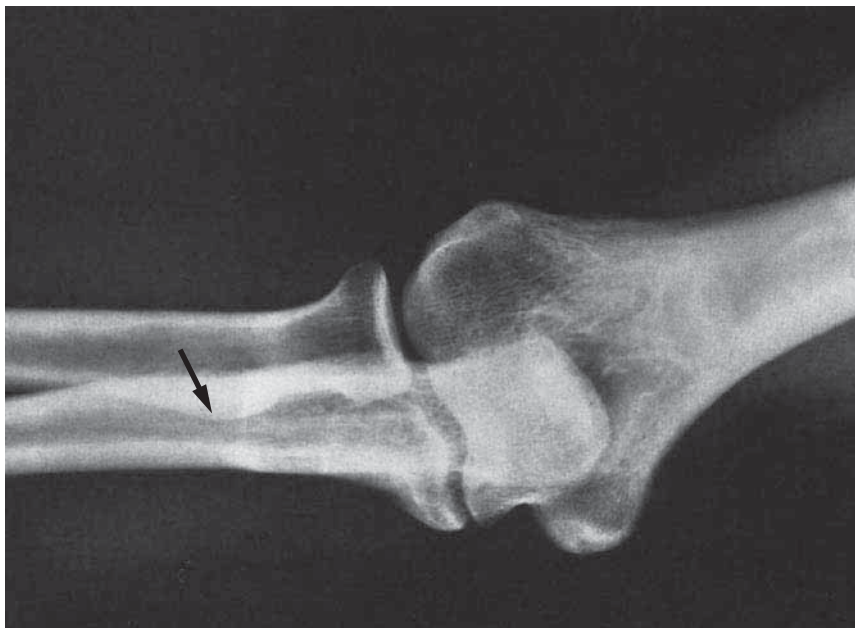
Radiograph of the Left Elbow Joint in an Adult (Lateral View)
